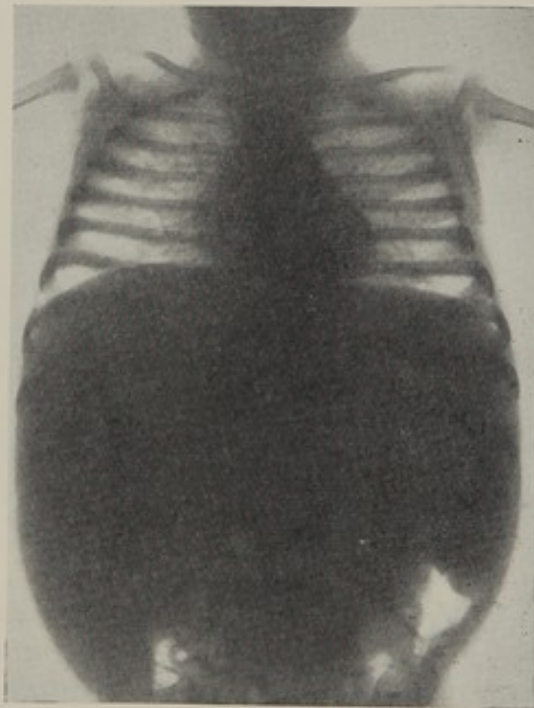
Roentgenogram of a boy aged 1 year affected with Niemann-Pick disease. (By courtesy of Dr. U. Pfändler.) Note the enormous hepatomegaly and splenomegaly, and the thickening of the pulmonary fibrous framework owing to deposits of lipids responsible for the opacification, and micro-nodular and trabecular aspect.
